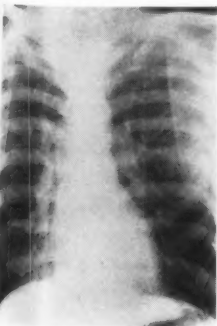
Radiograph of lungs of maker of electrolytic iron oxide showing fine generalised stippling or micro-nodulation due to deposits of iron oxide dust in the lymphatics of the lung.
